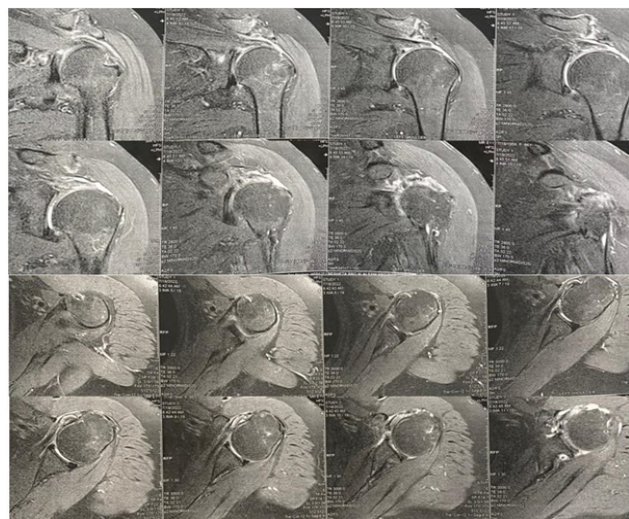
MRI of left shoulder (coronal and axial cuts) showing full-thickness tear.
